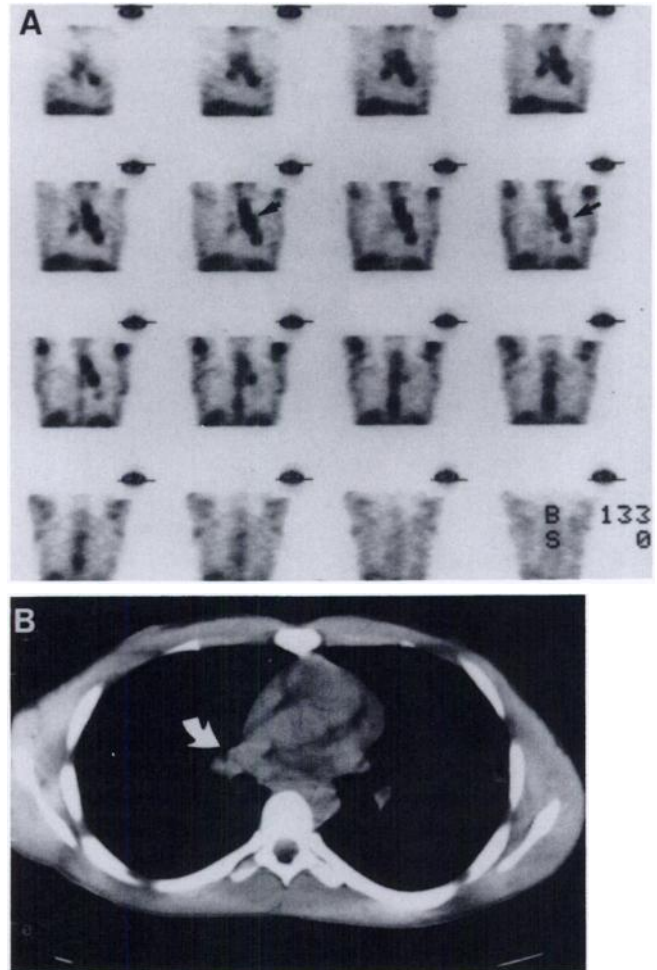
(A) A 21-yr-old male with nodular sclerosing Hodgkin's disease completed chemotherapy 10 wk prior to imaging and was then referred for restaging of the disease. SPECT images on coronal sections depict diffuse increased ^{67}Ga uptake in distribution of left paratracheal, hilar and anterior mediastinal lymph nodes, representing recurrent Hodgkin's disease. (B) CT scan of the same patient displays suggestion of enlarged lymph nodes in the right hilar region (arrow). However, this finding could not be differentiated from fibrosis and therefore could not be precisely interpreted as recurrent disease. Subsequent biopsy of the corresponding lymph nodes revealed recurrent Hodgkin's disease.
